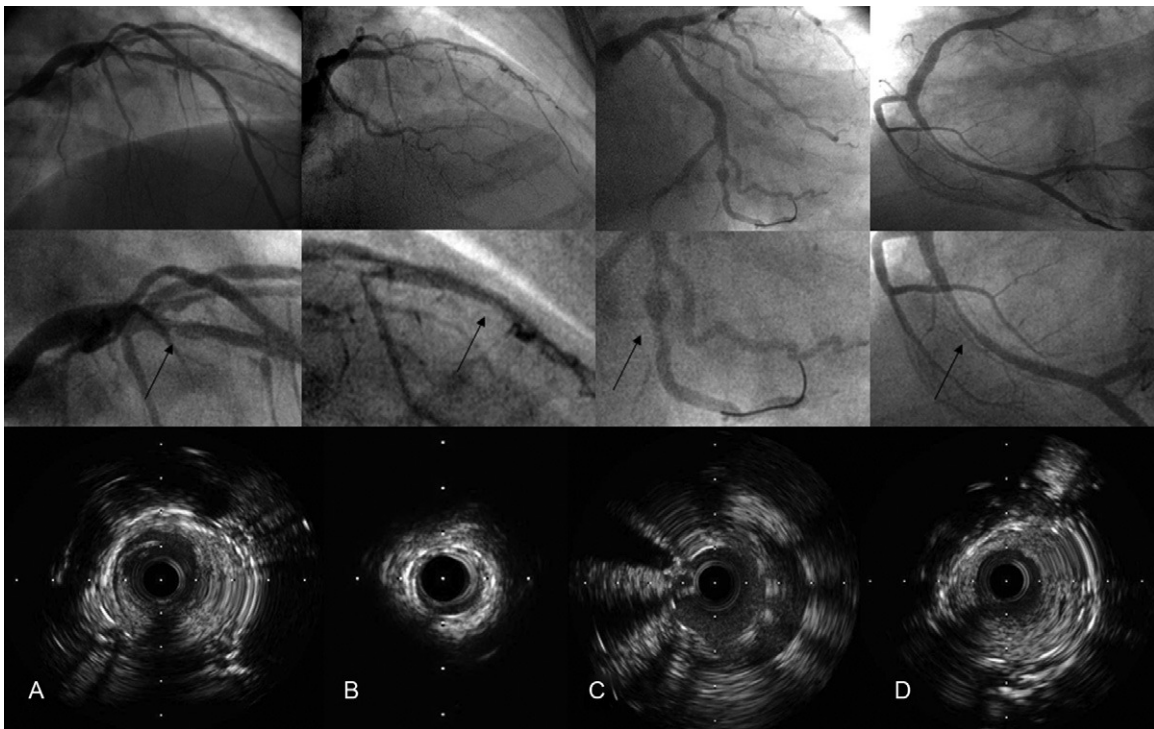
Four main mechanisms of stent thrombosis. The upper row shows the coronary angiographies once distal flow is recovered, the middle row provides a zoomed view of the stent, and the bottom row contains intravascular ultrasound cross-sectional images. A: Intimal flap at the stent border. B: Stent underexpansion. C: Malapposition due to positive vessel remodeling. D: Neointimal proliferation with severe stenosis.
